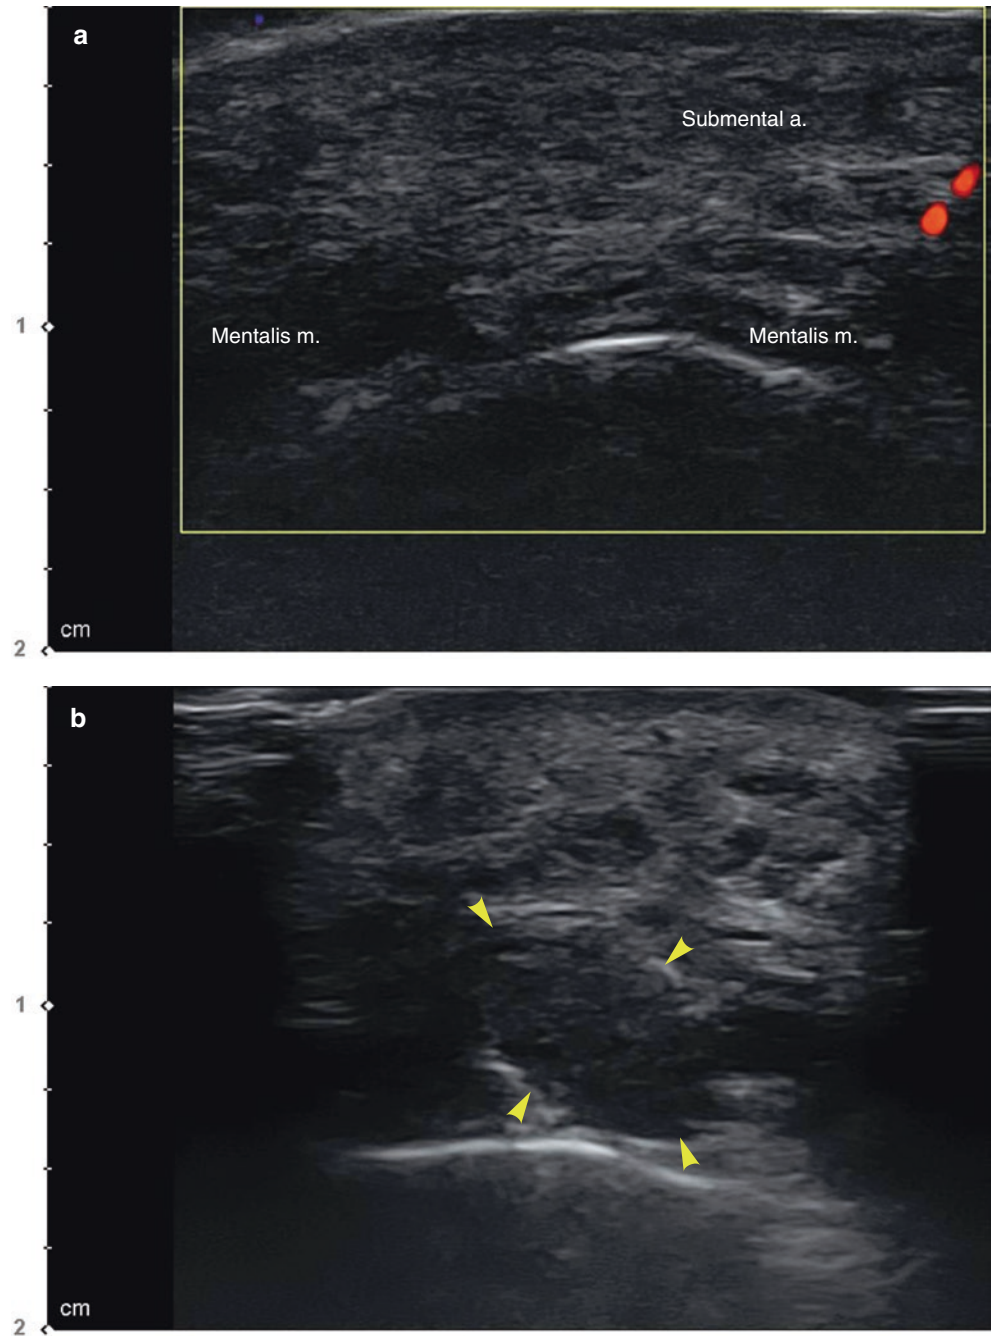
Ultrasonography of HA filler for the marionette line improvement, Doppler mode (transverse view, 15 MHz by linear transducer) (yellow arrowheads: HA filler). (Published with kind permission of © Ji-Soo Kim 2020. All Rights Reserved)
